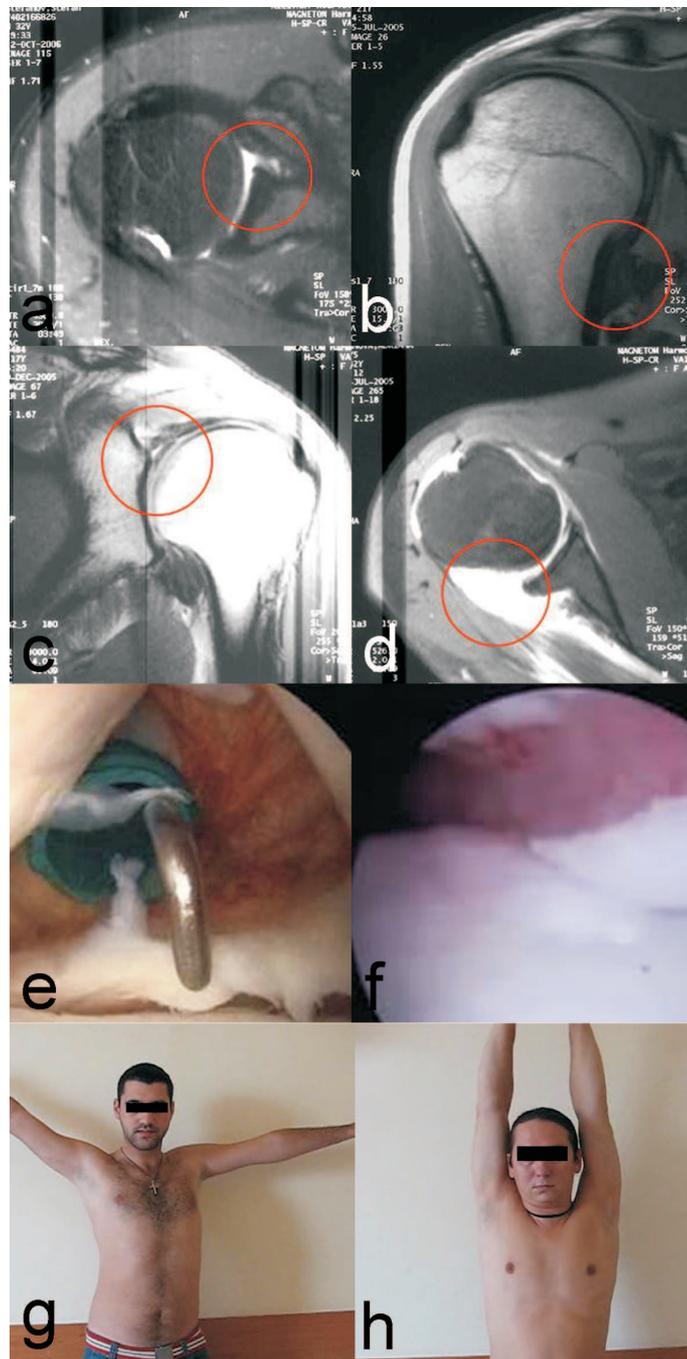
a-d: MRI of the shoulder joint. a – presence of Bankart lesion; b – ligament lesions; c – ligament lesions in combination with SLAP lesions; d – lesion of posterior labrum; e, f – arthroscopic findings presented enlarged inferior recessus of the capsule – “front-bottom pocket”; g – postoperative clinical examination 15 days after immobilization; h – postoperative clinical examination 3 months after immobilization
